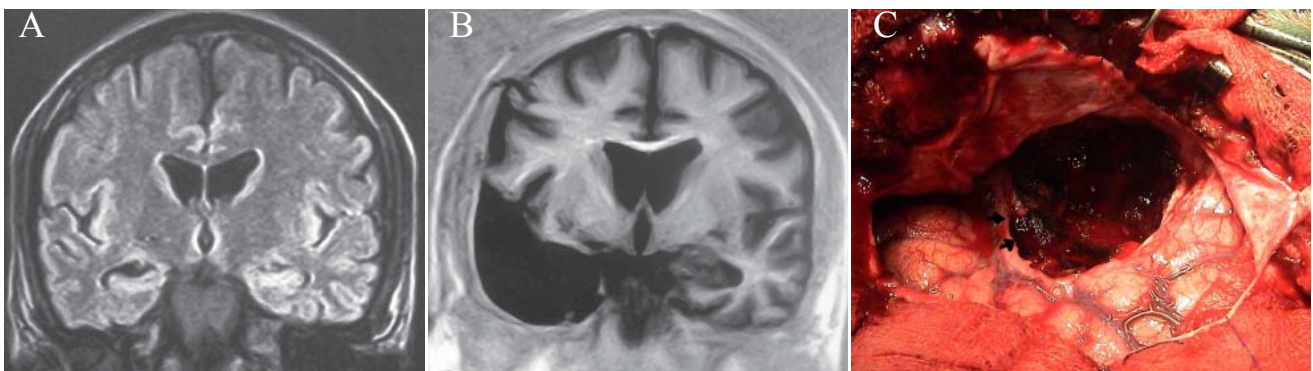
A: Preoperative MRI, FLAIR coronal section of patient 1 showing right hippocampal sclerosis, B: post operative image showing classical ATL where the hippocampus and the amygdala are also removed, C: Intraoperative photograph showing the extent of the surgical resection. Note that the dissection in the Sylvian fissure is subpial (arrow).
